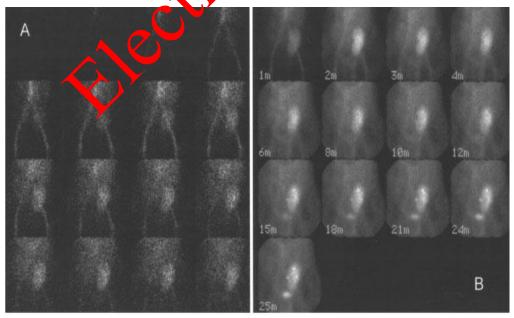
Renal scintigraphic study with 99mTc-DTPA of a patient with acute rejection. A) Flow phase. Note the moderate reduction of the flow to the graft. There is moderately reduced accumulation, concentration and excretion of the radiotracer.
